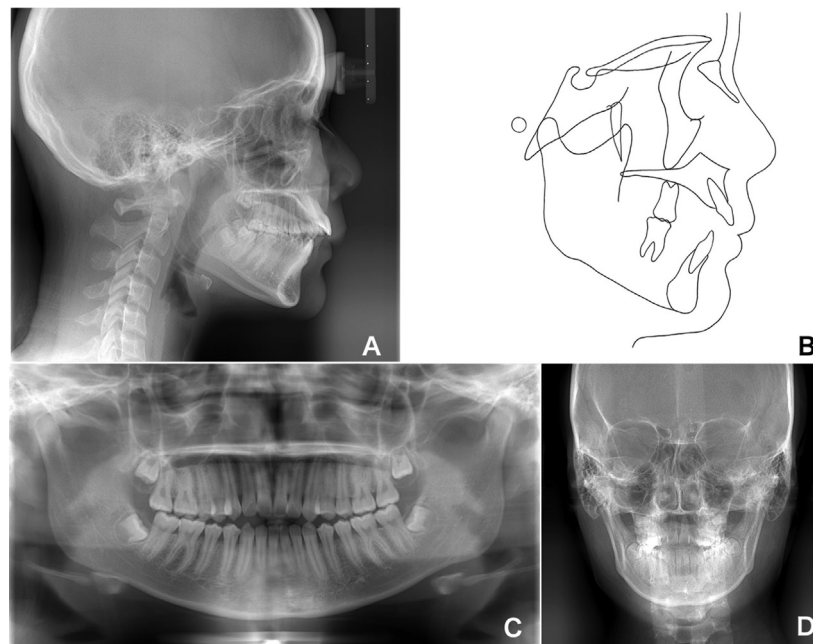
Patient 1: A, pretreatment cephalometric radiograph; B, cephalometric tracing; C, panoramic radiograph; D, PA radiograph.
